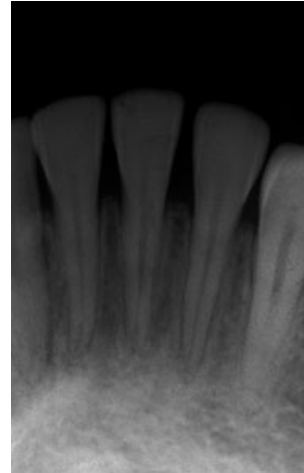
Radiograph taken 8 months after trauma. Minor signs of irregularity in the root canal of the lower left first incisor are seen.
